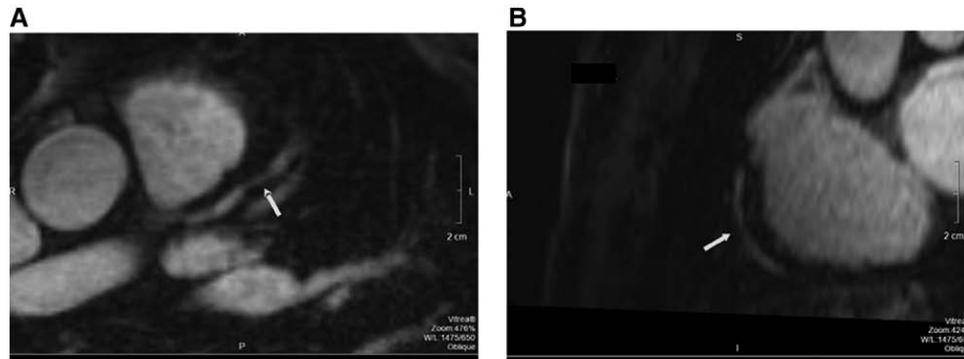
Cardiac MRI revealing mid vessel narrowing (arrows) in the mid LAD (A) and mid RCA (B). LAD indicates left anterior descending artery; and RCA, right coronary artery.
